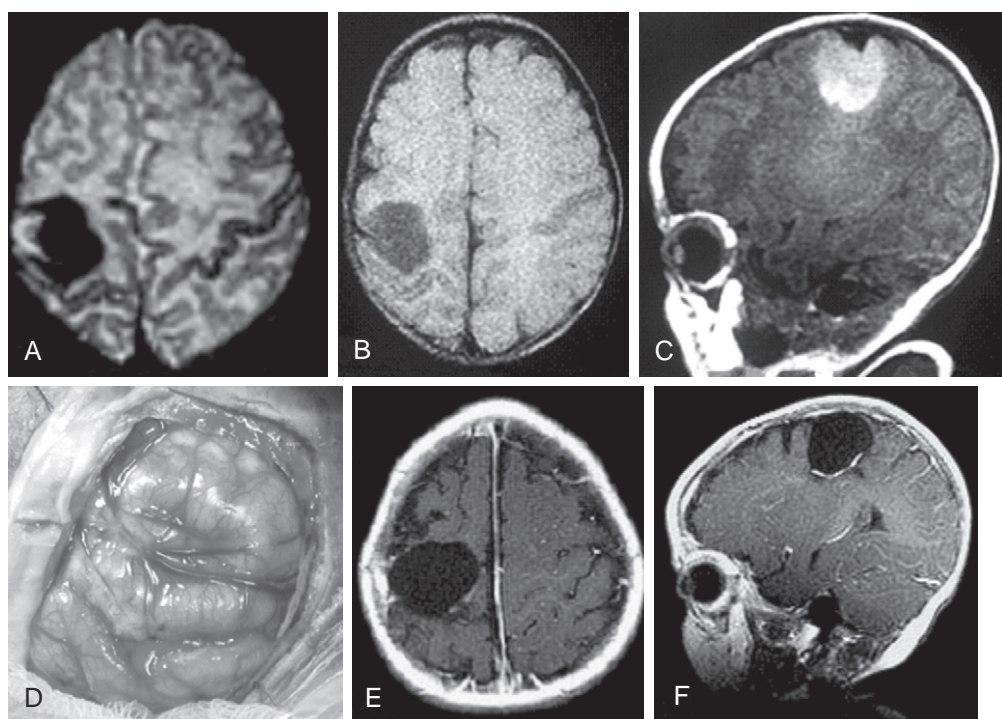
Three-month-old girl with 30 to 60 seizures per day on three anticonvulsants. A to F, Brain magnetic resonance image (MRI) showing a $2.5 \times 2.5 \times 2$ -cm right posterior frontal mass. Preoperative video electroencephalographic studies localized her seizures to the region of the abnormality on MRI. She underwent complete resection of the mass and adjacent epileptogenic zone, which was localized via intraoperative electrocorticography. The final pathology was a ganglioglioma. She is now 33 months of age with no evidence of tumor recurrence, has mild residual spastic left hemiparesis, and is completely seizure free and off all anticonvulsants.
